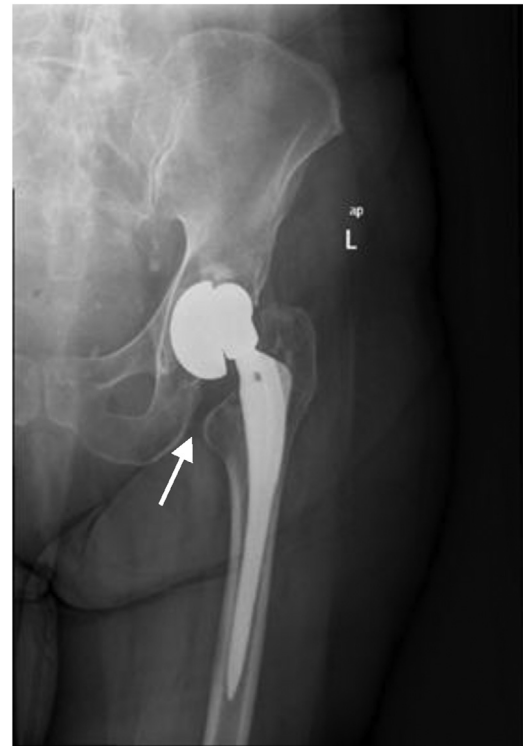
Anteroposterior radiograph demonstrating a dissociation of a left hip bipolar hemiarthroplasty. The outer head is in extreme varus position (arrow)—osteoarthritic changes of the acetabulum.
